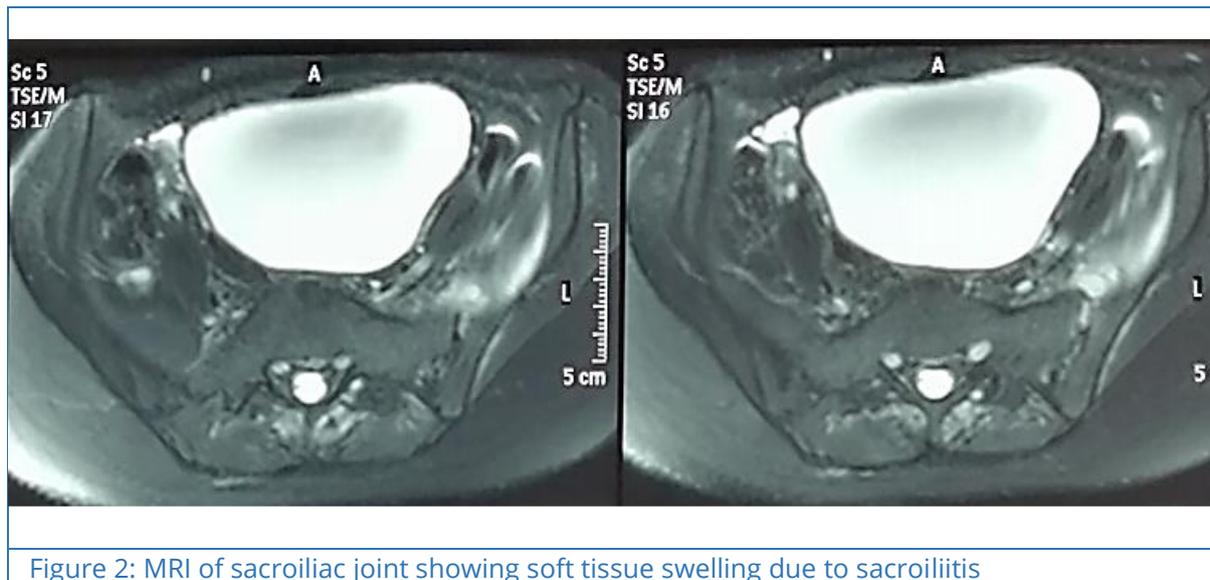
MRI of sacroiliac joint showing soft tissue swelling due to sacroiliitis
